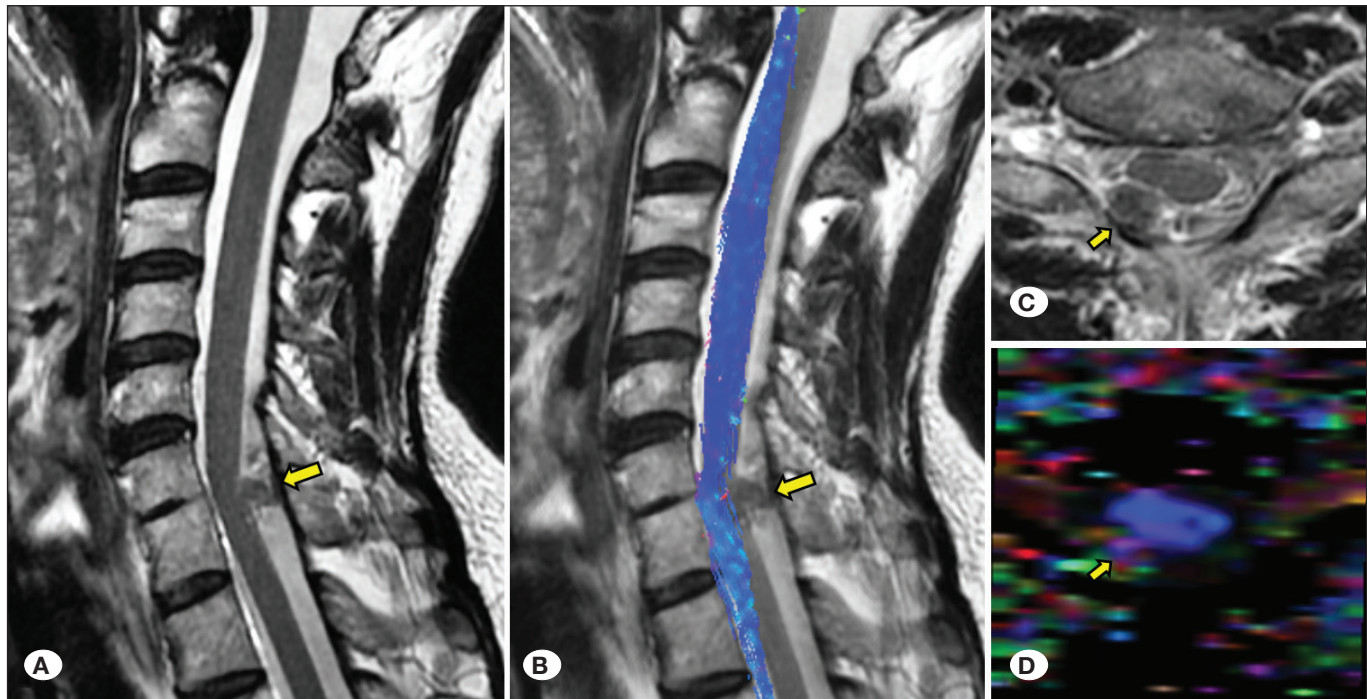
A 60-year-old woman with head and neck pain had a meningioma at C6–C7 (yellow arrows) with minimal displacement of the spinal cord tract. T2-weighted sagittal image (A), tracts superimposed on a T2-weighted sagittal image (B), a T2-weighted fat-saturated axial image (C), and a color-coded FA map (D).
